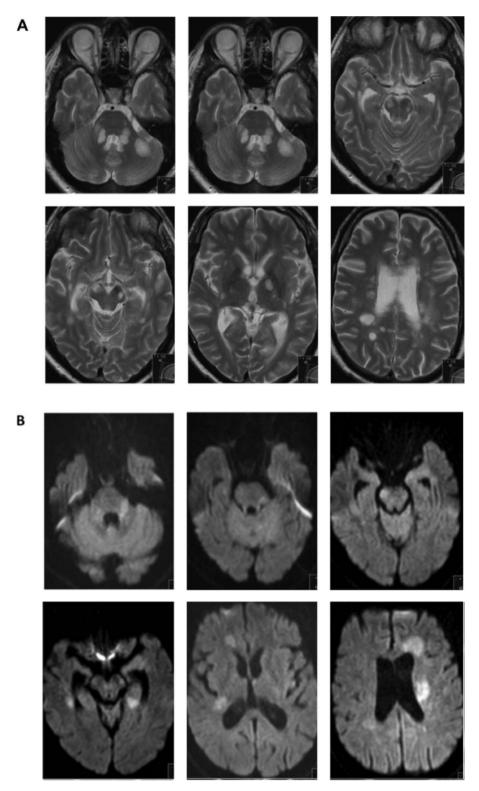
Axial MRI scans of a patient with relapsing-remitting Multiple Sclerosis. (A) T2-weighted images from caudal to cranial (from upper left to lower right), taken at a time at which the patient was severely physically impaired but did not yawn. (B) Three months later the same patient presented with bouts of highly abnormal yawning (sometimes up to 1 yawn every min) due to a new relapse. Only diffusion-weighted-imaging (DWI) scans could be made due to the patient's restlessness in the scanner. As both T2 and DWI are spin echo sequences, they can be compared to a certain extent. Abnormal yawning was accompanied by new lesions: in left hippocampus, perhaps in the median line of the mesencephalon and the right caudal insula, the corpus of the left caudate nucleus, and in the area of frontal commissural fibers on both hemispheres. Otherwise, an alteration in size and signal intensity of preexisting lesions was seen.
